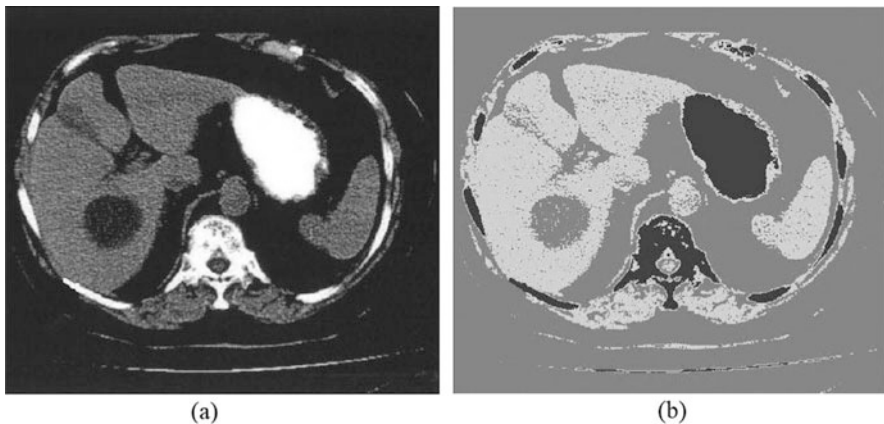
An example of thresholding segmentation. (a) Original abdomen CT image and (b) segmented abdomen CT image by thresholding technique (Aggarwal 2010)
